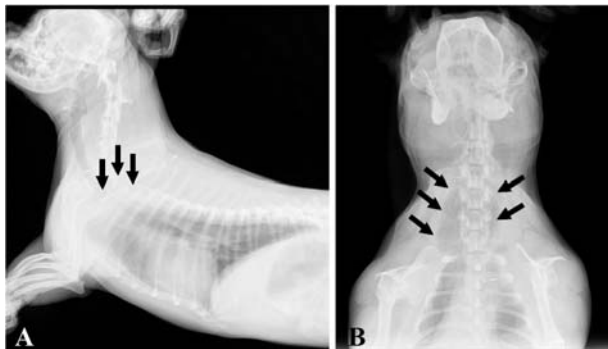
Thoracic radiography in this case. (A) Right lateral projection of thoracic radiography found the protrusion (arrows) of cranial portion lung lobe beyond the thoracic inlet. (B) Ventrodorsal projection of thoracic radiography revealed the protrusion (arrows) of cranial portion lung lobe beyond the thoracic inlet. The lung lobe herniation projected 12 cm cranial to the thoracic inlet at its peak.
